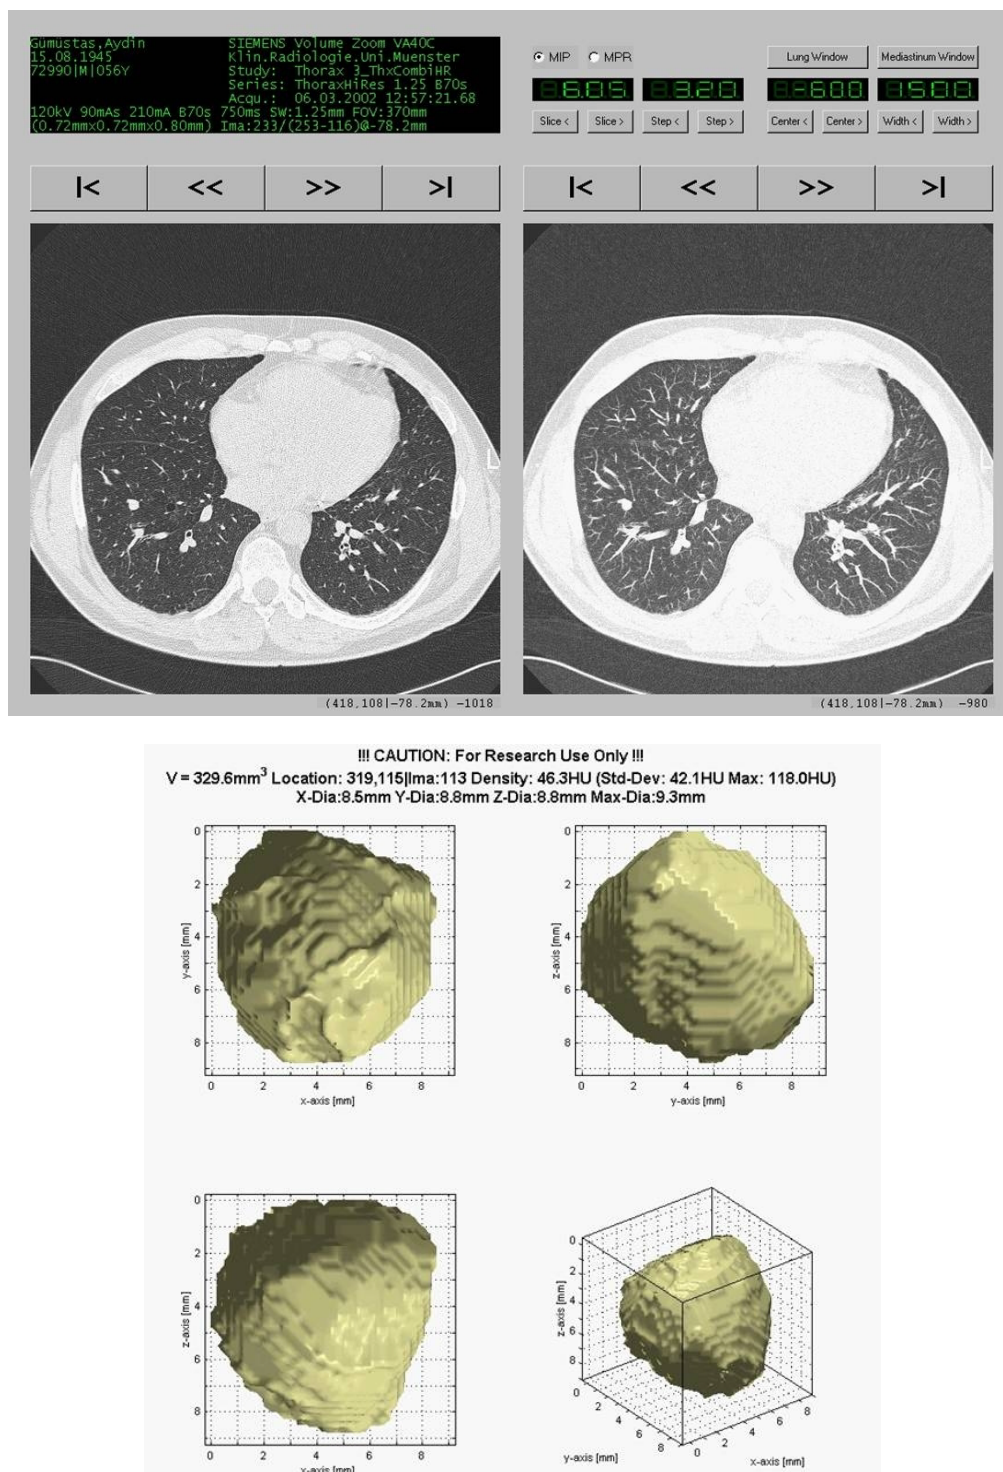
Example of computer-assisted volumetry at low-dose CT (prototype Lung care™ software, Siemens Corporation, Erlangen, Germany). (a) Thin-section image (left) and thin-section sliding maximum intensity projection (right) at the level of the inferior pulmonary veins showing a central pulmonary nodule in the right lower lobe. (b) Segmented nodule with indication of diameters, volume and density of nodule.
